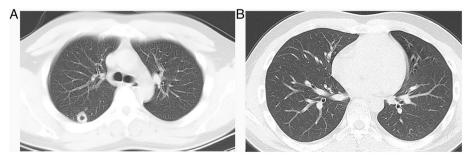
Computed tomography scan of the chest in case 21. Cavitation, pleural thickening, and pleural effusion in the right lung (A). Nodules, spots, and cord shadows were observed in the right lower lobe and right upper lobe of the lung (A, B)
